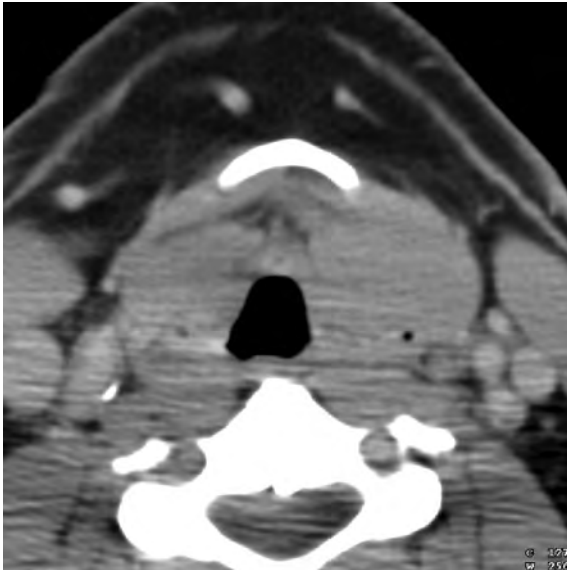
Laryngeal NHL. Axial contrast-enhanced CT-image at the lower border of the hyoid bone shows bilateral large submucosal masses (Courtesy I. M. Schmalfuss, MD, Gainesville, Florida)
